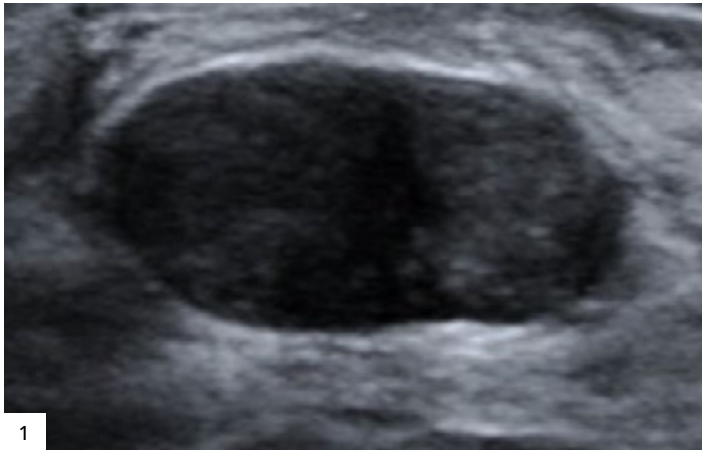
Classic fibroadenoma on ultrasonography. A 27-year-old woman presented with a left breast lump felt on her first-ever breast self-examination. Since the patient is a woman younger than 30 years, mammography was deferred. Focused sonographic evaluation of the left breast at the area of palpable concern revealed an oval, parallel, circumscribed, hypoechoic mass without definite posterior features, measuring up to 2.2 cm, favored to represent a fibroadenoma and appropriately assessed as BI-RADS 3. If the lesion were definitely new or enlarging, it would have been given a BI-RADS 4 assessment with recommendation for biopsy.
